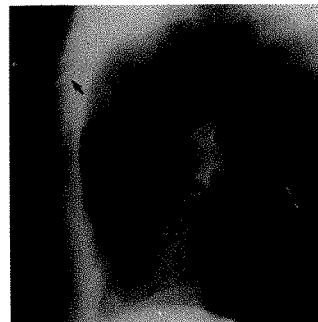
Lateral chest radiograph shows Tru-Close Thoracic Vent (arrow) is outside pleural space.
